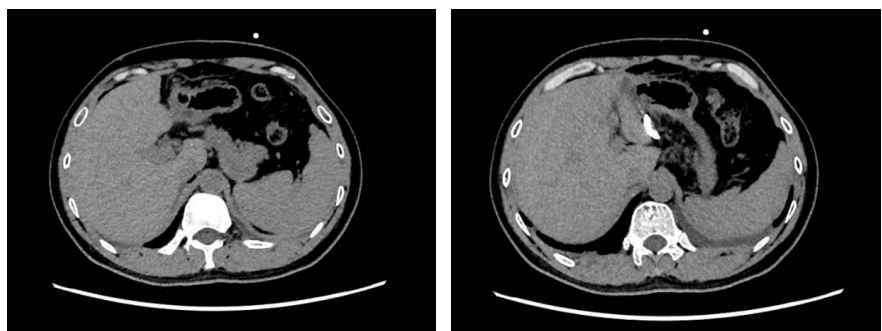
A computed tomography scan of the entire abdomen indicates the absence of a notable effusion.
